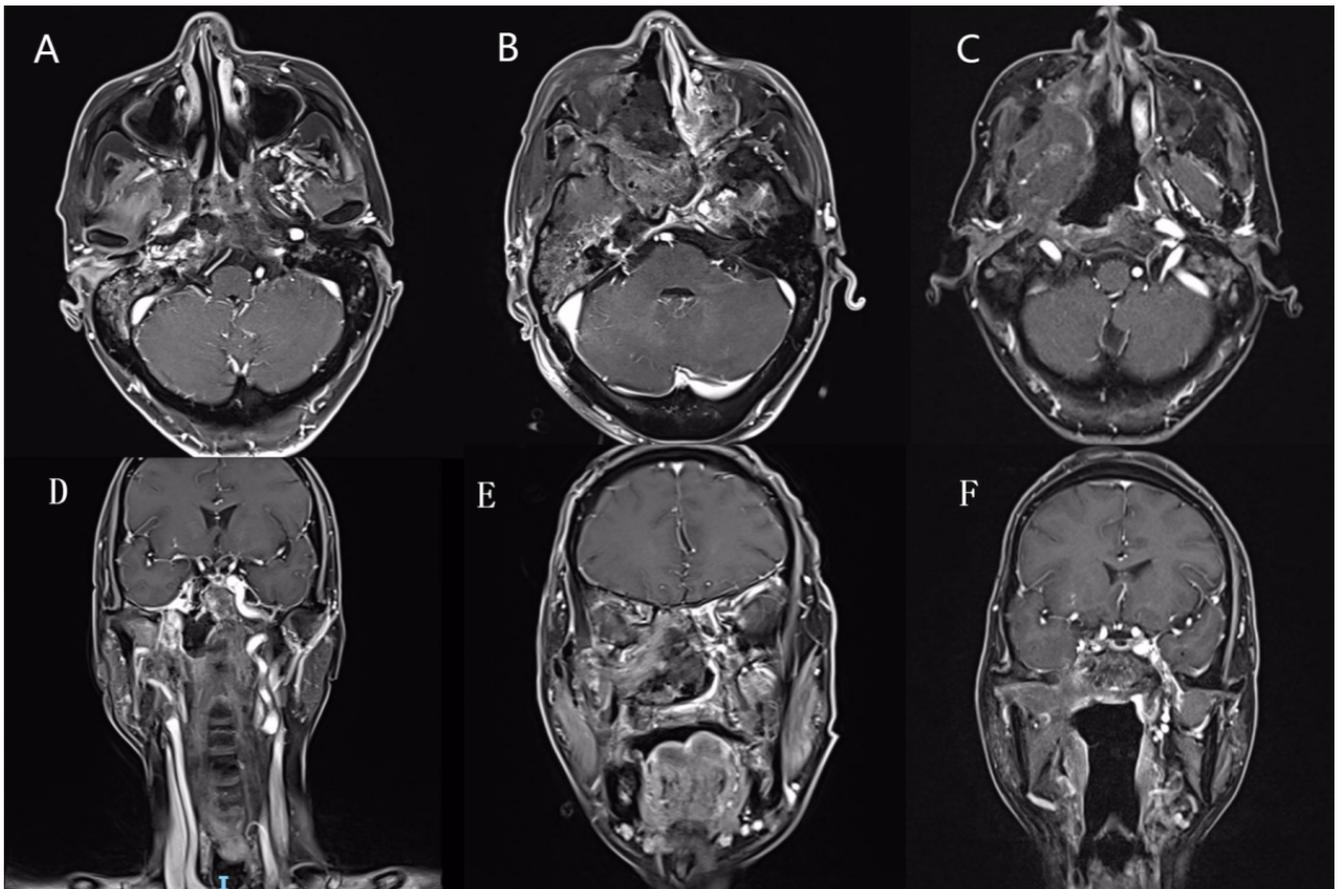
Enhanced magnetic resonance imaging (MRI) before and after surgery. (A) Horizontal and (D) coronal MRI showing the necrosis partially invading the right ICA. (B)(E) One day after surgery, the right ICA was embolized, and part of it was resected. A temporal muscle flap was used to repair the skull base defect, and the nasal cavity was packed. (C)(F) One year after surgery.
